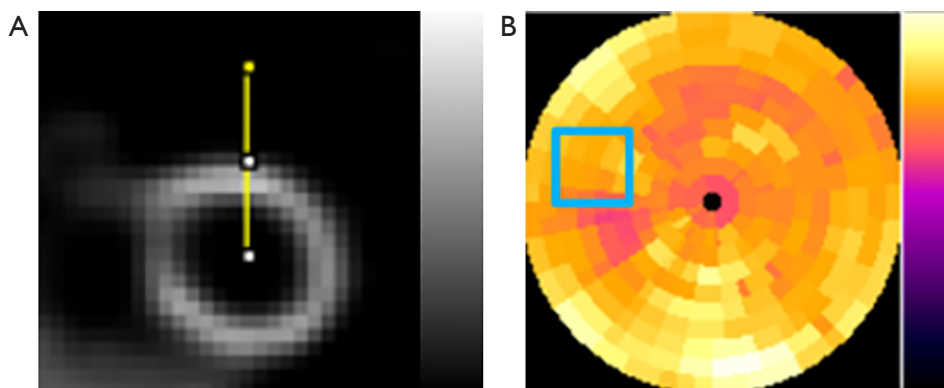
The ROIs used for data analysis in this study. (A) 3D VOI chosen from denoised SPECT images for measuring NMSE and SSIM. The yellow line indicated the profile drawn across the cardiac wall for measuring the FWHM. (B) The CV value measuring from the selected ROI (blue box) on the polar plots. ROI, region-of-interest; VOI, volume-of-interest; NMSE, normalized mean square error; SSIM, structural similarity index; FWHM, full-width-at-half-maximum; CV, coefficient of variation.
